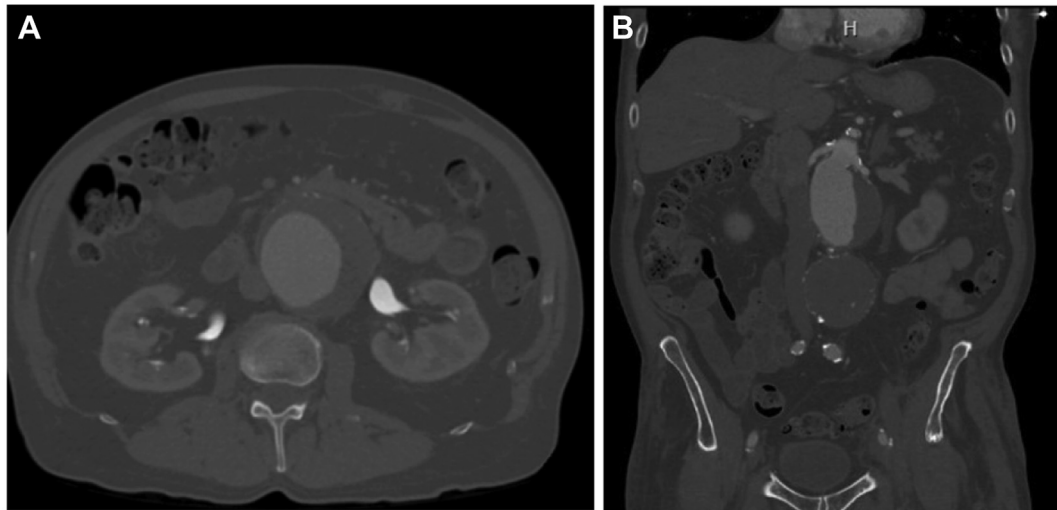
Representative (A) axial and (B) coronal images of a computed tomography angiography scan of a patient with a juxtarenal aneurysm.
